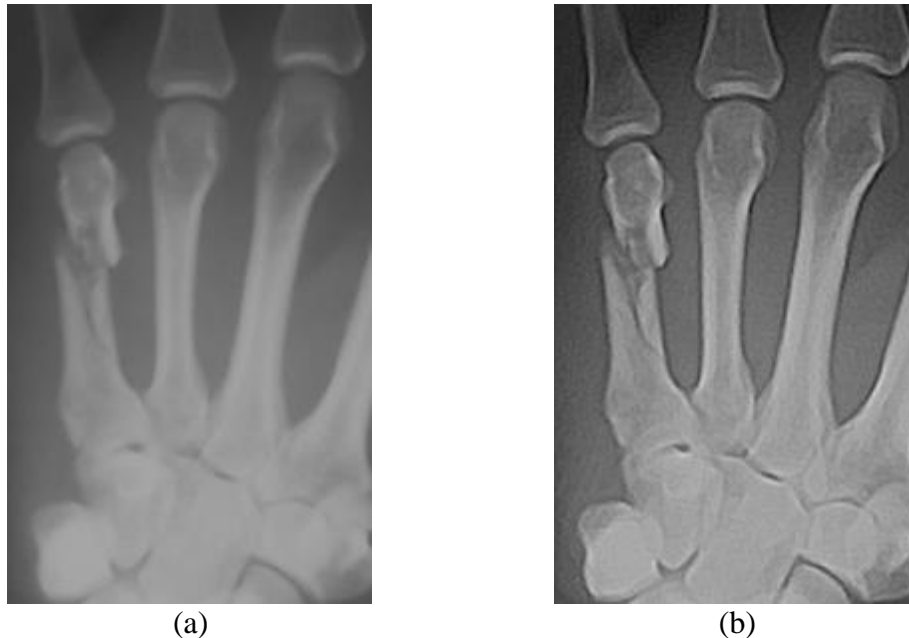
Morphological filtering for X-ray hand image enhancement. (a) Original image. (b) After enhancement.
